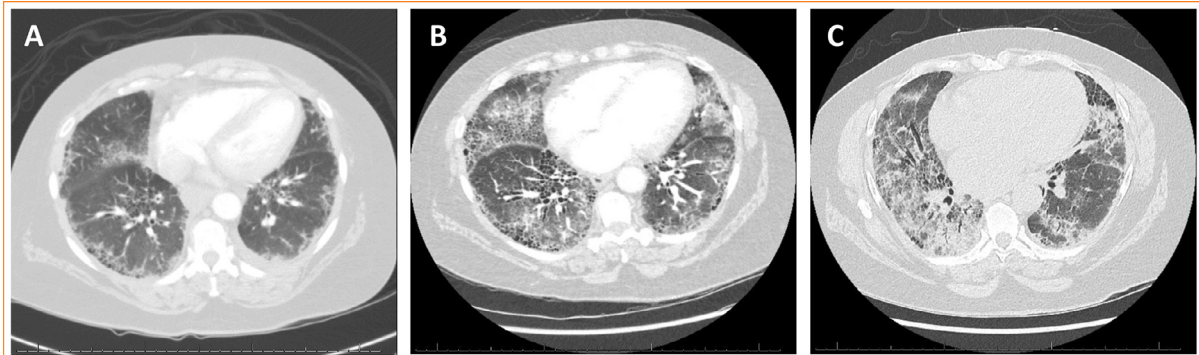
Chest CT scan of patient with RA-ILD and COVID-related exacerbation. A, Baseline chest CT scan showing bilateral and peripheral infiltrates with some areas of honeycombing interpreted as consistent with UIP pattern. B, Chest CT scan during hospitalization showing bilateral ground glass opacities with underlying ILD. C, Chest CT scan obtained during second hospitalization showing worsening of infiltrates. *Abbreviations:* CT, Computed Tomography; ILD, interstitial lung disease; RA-ILD, rheumatoid arthritis associated interstitial lung disease.
